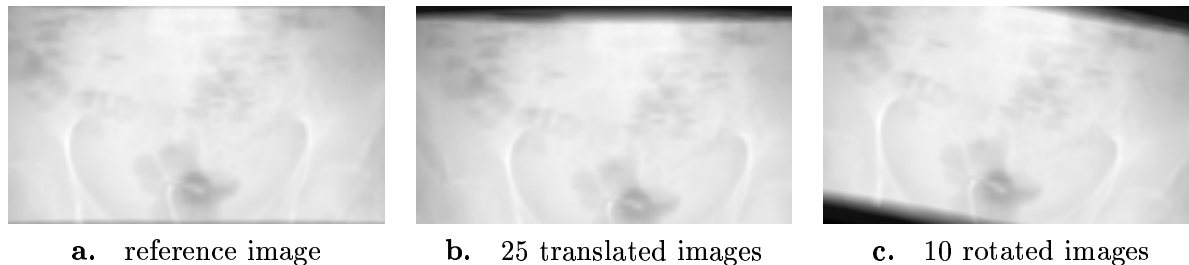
In-plane test series computed from CT volume. The CT is translated and rotated in the image plane.
